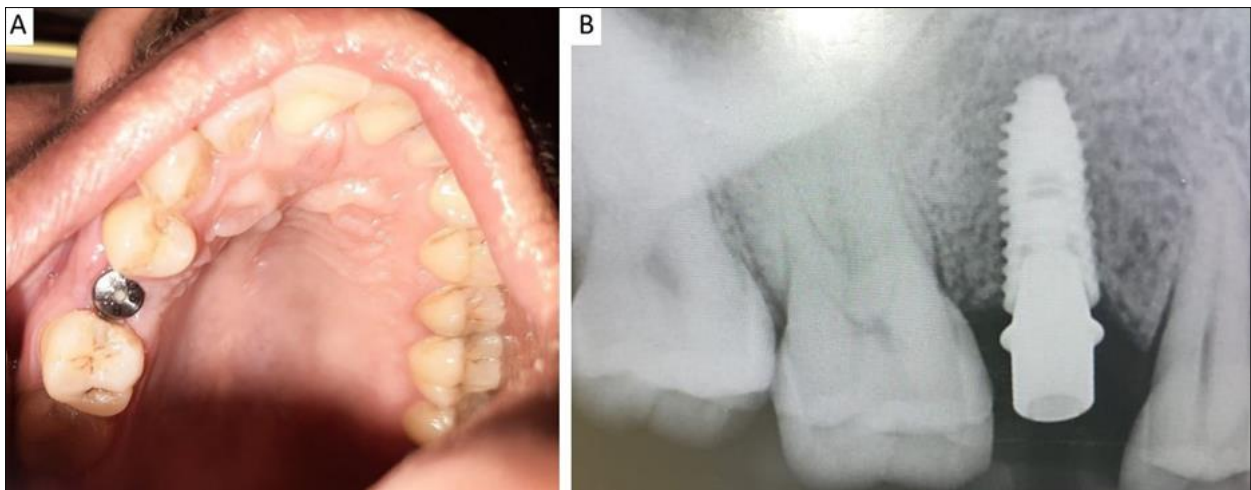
Healing abutment in place A) on clinical examination; and B) in intraoral periapical radiograph
